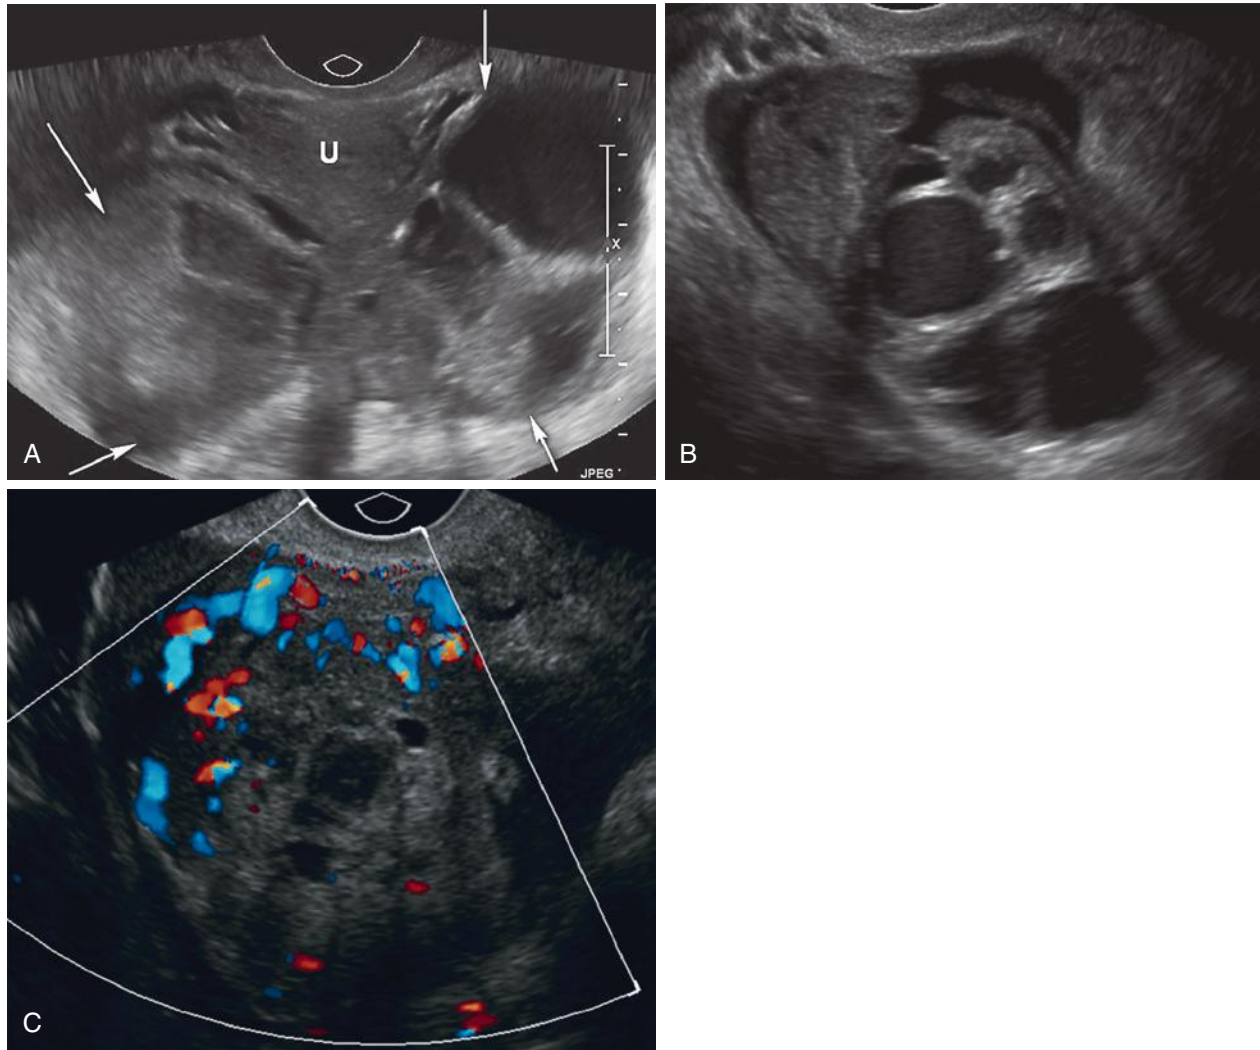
Tubo-ovarian abscess (TOA). A, Transverse gray-scale view of the uterus (U) with bilateral TOAs (arrows) demonstrating solid and complex cystic components with ill-defined borders. No normal-appearing ovary could be identified on either side. B, Another patient with TOA. Note the complex, multilocular adnexal mass with surrounding free fluid. The ovary and tube are not discretely recognizable. C, In a third patient with a TOA, note increased vascularity on color Doppler image of more solid appearing, markedly tender adnexal mass.
